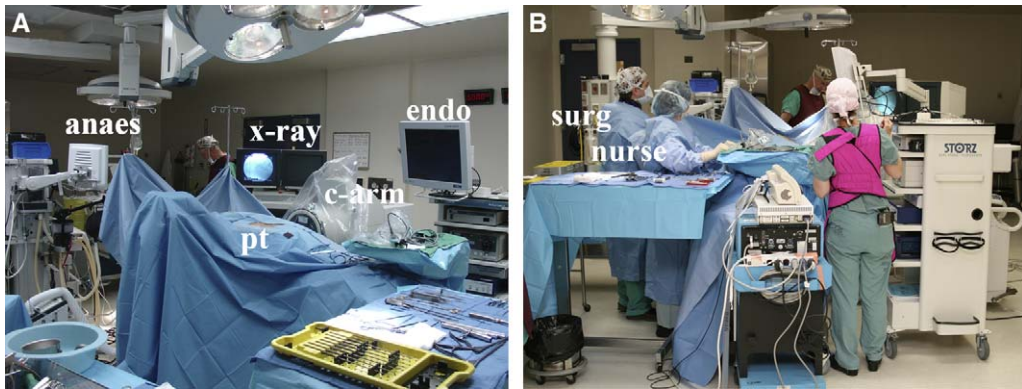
(A, B) Orthogonal views of the operating room setup for MED. The patient (pt) is positioned prone on a radio-lucent frame. The surgeon (surg) stands on the patient's symptomatic side, along with the scrub nurse (nurse). The anesthesia team (anaes) is positioned at the patient's head for easy access to the endotracheal tube if needed. The fluoroscopy unit (c-arm) is brought in opposite the surgeon. The video display for the endoscope (endo) and the fluoroscopy unit (x-ray) is also positioned opposite the surgeon and in easy view.
